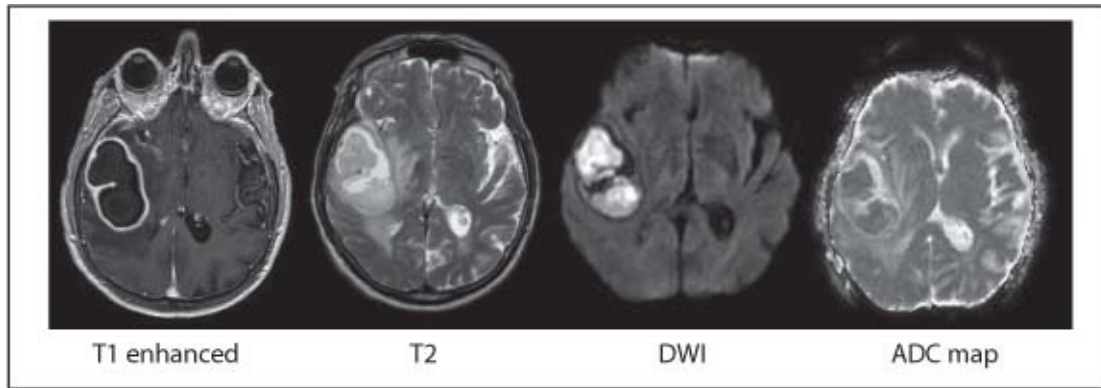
MRI of right hemispheric cerebral abscess (bright on DWI)
